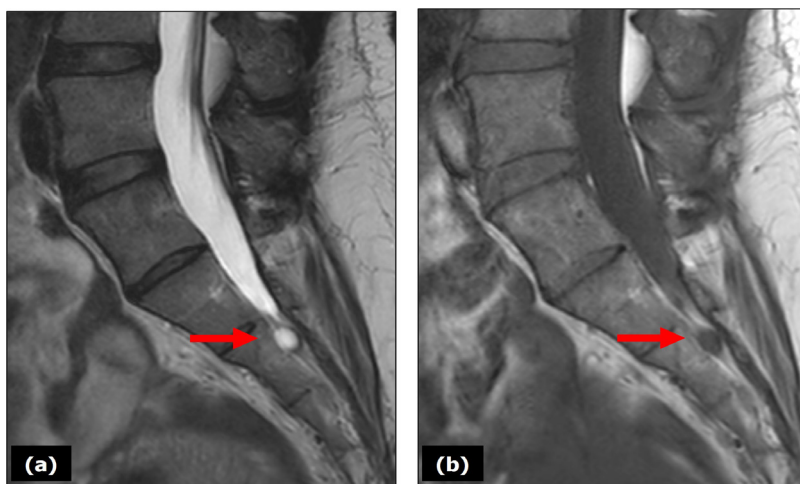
(a) Sagittal T2-weighted and (b) sagittal T1-weighted MRI images of the lumbosacral spine. The red arrows pointed to a Tarlov cyst at the S2 level. On the T2-weighted image, the cyst appeared hyperintense (bright), reflecting its fluid content consistent with cerebrospinal fluid (CSF). In the T1-weighted image, the lesion was isointense to the CSF. The cyst was located within the sacral canal.
